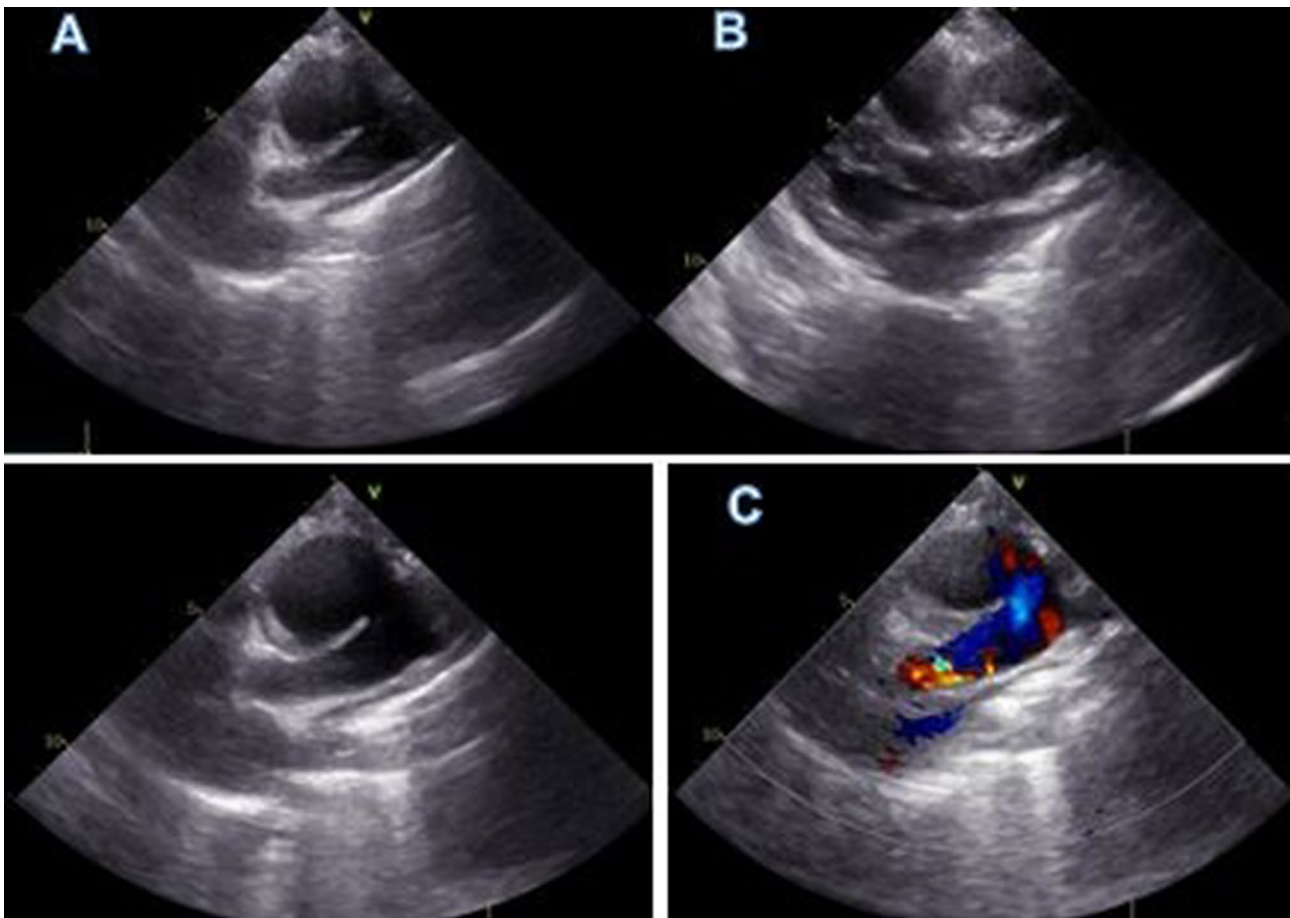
Echocardiographic findings in suprasternal section. Severe dilatation of the ascending aorta that begins 20 mm from the sinotubular junction, where a 12 mm aneurysmal mouth is observed in the long axis sternal plane, the diameter of said aneurysm is 40 by 70 mm with a thrombosed area inside and spontaneous contrast. Diameter of the ascending aorta prior to the aneurysm is 15 mm and the aortic root is 16 mm
